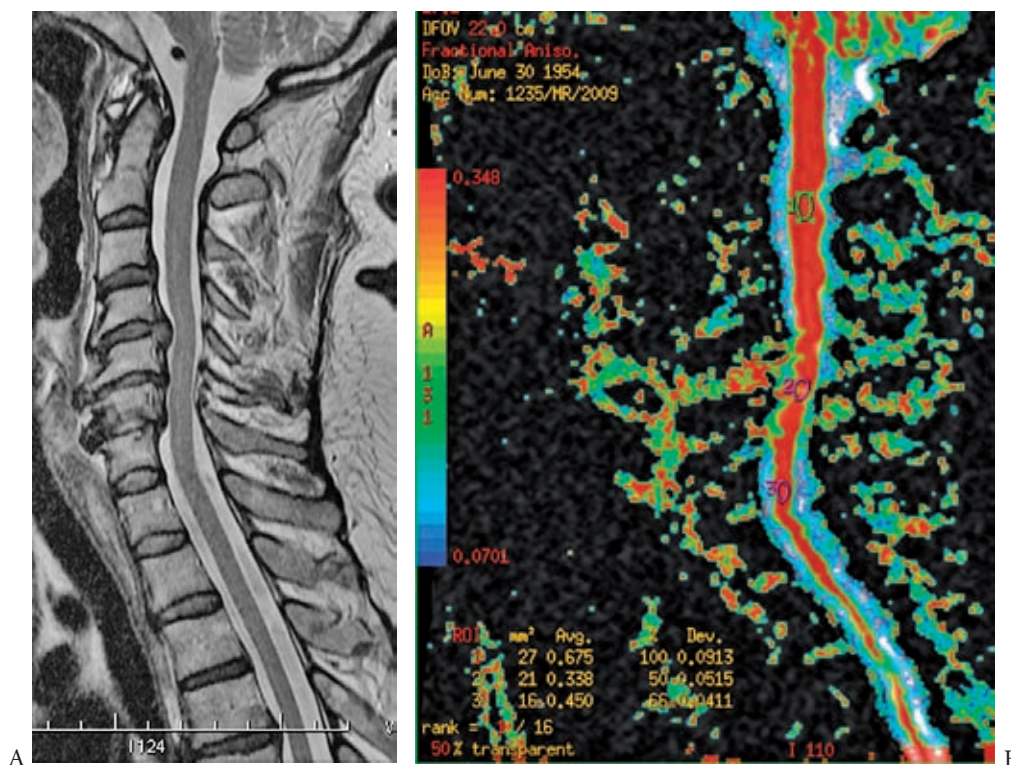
MR, sagittal plane, T2-weighted image (left) and diffusion tensor imaging (DTI) (right). Spinal stenosis at the C4/C5, C5/C6 and C6/C7 levels with compression of the spinal cord. No abnormal signal is seen in the spinal cord at these levels. However, on the DTI there are multiple foci of decreased fractional anisotropy (FA) in the anterior part of the spinal cord, which are compatible with degenerative injuries of the spinal cord due to chronic compression
